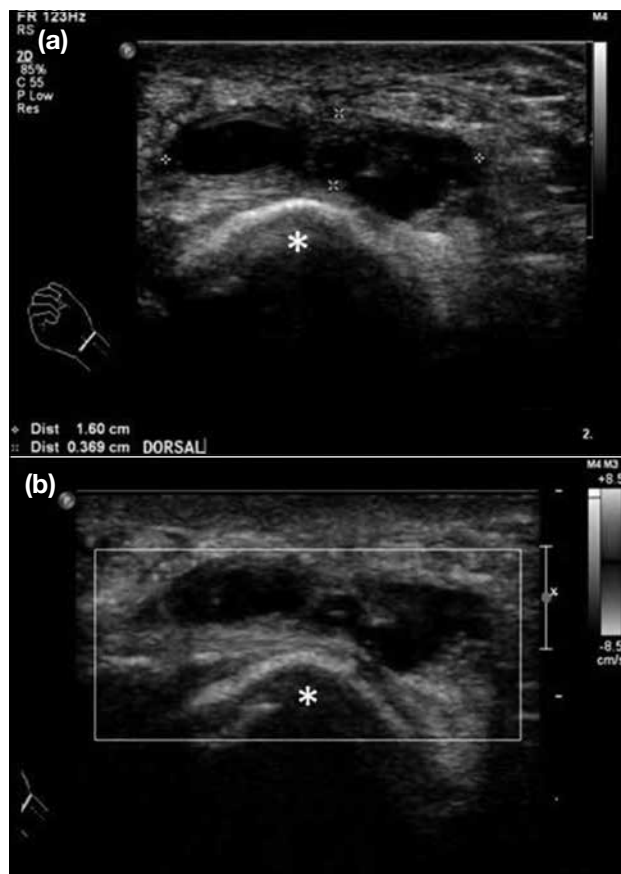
Ganglion cyst in a 37-year-old woman who presented with right wrist mass: (a) Sonographic examination of the dorsal side of the right wrist showing multiloculated hypoechoic lesion at the radial aspect of the dorsal right radius (asterisk). (b) No internal vascularity is evident.
